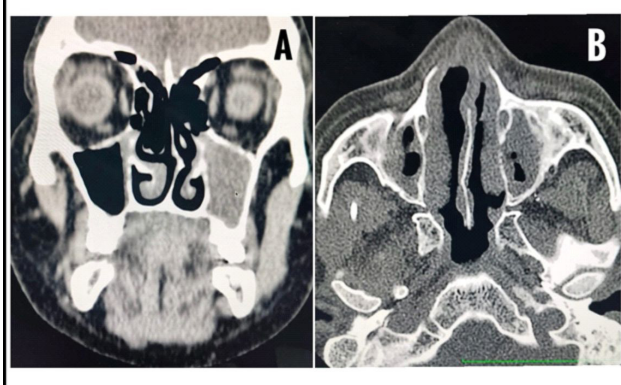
A- Coronal CT showing bilateral maxillary sinusitis (left >right) with obliteration of left osteomeatal complex containing hyperdense foci likely representing fungal sinusitis. 4B-Axial CT PNS showing mucosal thickening in bilateral maxillary sinusitis with hyperdense contents and rarefaction/remodeling of walls of maxillary sinuses likely representing fungal sinusitis.
